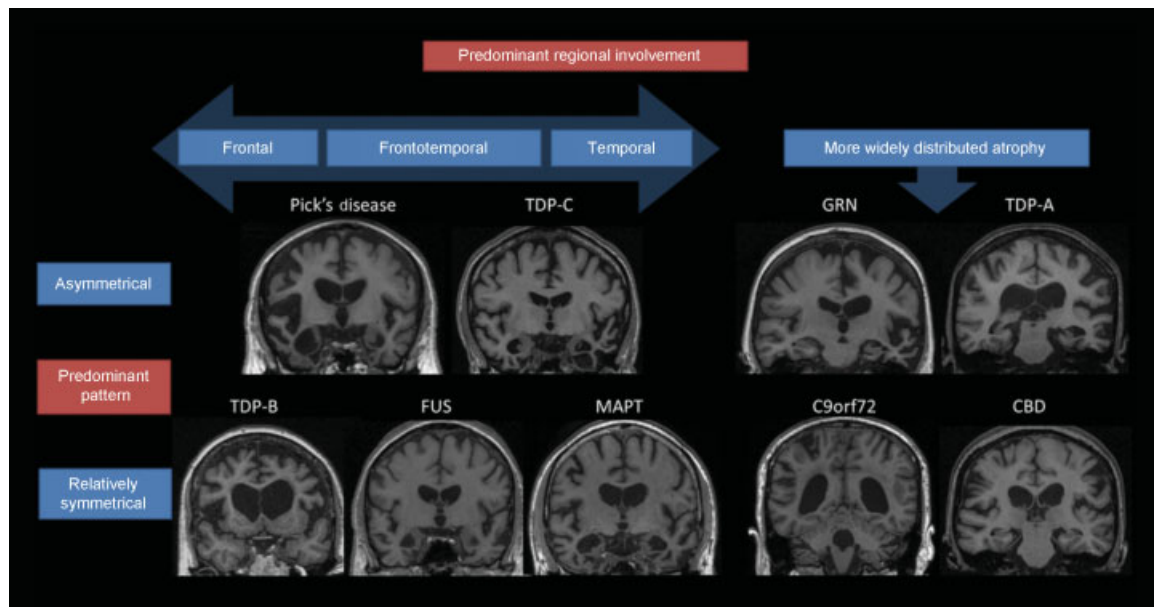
Neuroimaging in pathologically confirmed frontotemporal dementia (FTD) patients. T1 MRI images in genetic and pathological forms of FTD, highlighting pathological propensities toward symmetry and regional predilections. Figure used with permission from: Gordon E. Rohrer JD, Fox NC. Advances in neuroimaging in frontotemporal dementia. *J Neurochem* 2016;138:193–210. <https://doi.org/10.1111/jnc.13656>.
